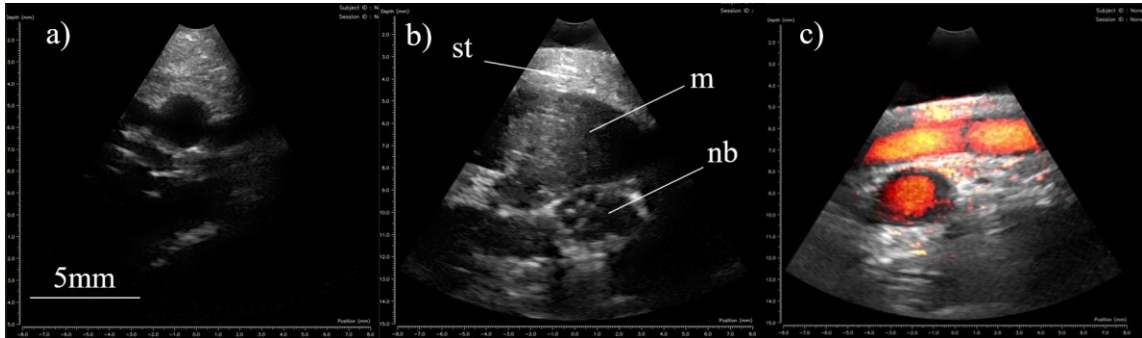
Images generated of a human wrist: a) Transverse view of wrist featuring three vessels b) transverse view of the wrist featuring muscle (m), subcutaneous tissue (st), and a nerve bundle (nb) c) power Doppler image of a deep transverse vessel and a superficial sagittal vessel in the forearm.
